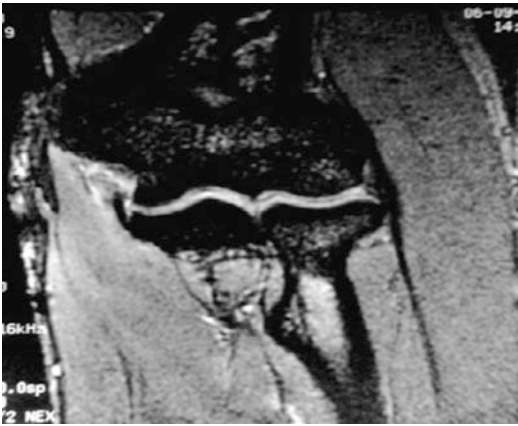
MRI was ordered, which revealed a full-thickness tear off the medial epicondyle of the anterior bundle of the UCL
